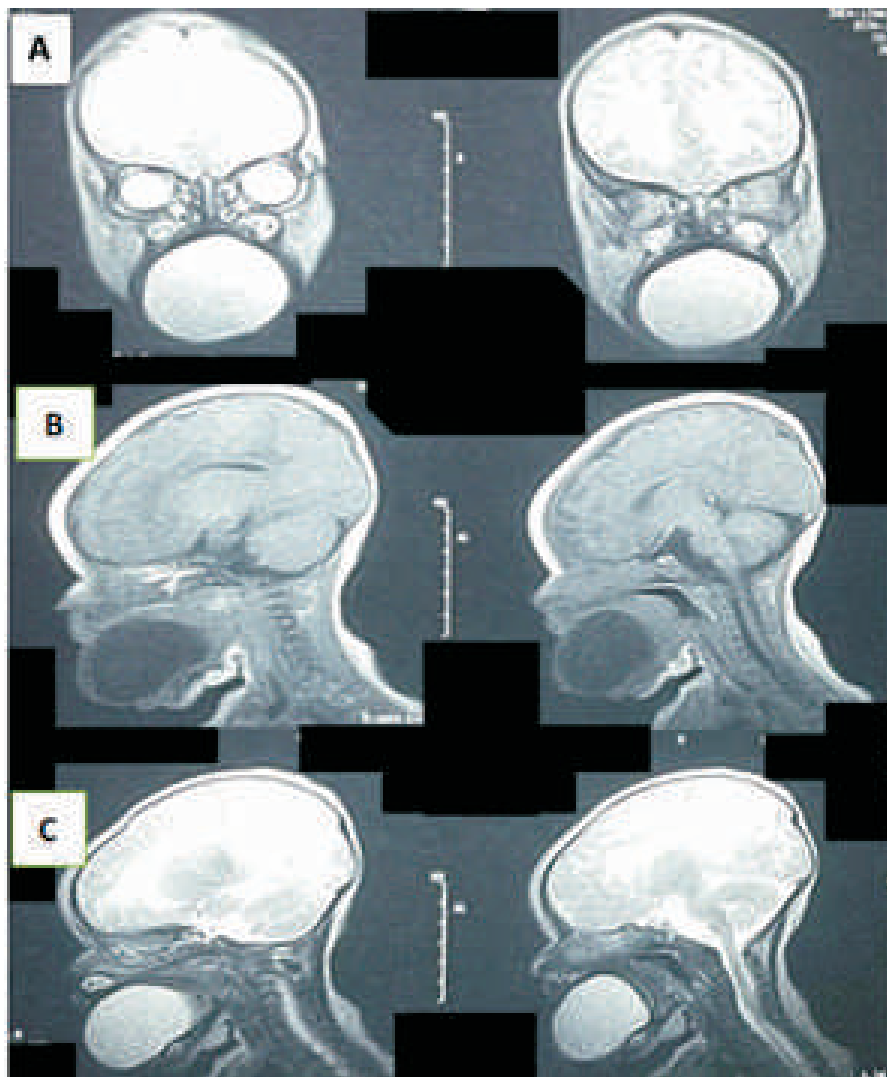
The cyst on MRI; Coronal T1W image showing a homogenously hypointense lesion(A), Sagittal T1W image showing a homogenously hypointense lesion(B) and Sagittal T2W image showing hyperintense lesion in keeping with dermoid of the tongue©
